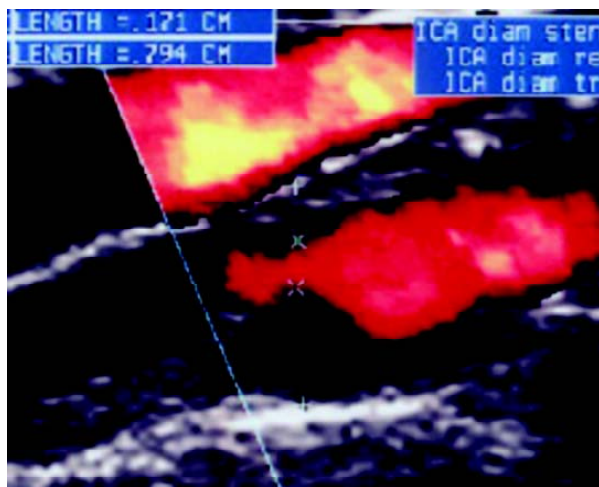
Internal carotid artery severe (85%) stenosis. Color Doppler ultrasound. Severe narrowing of artery lumen.
